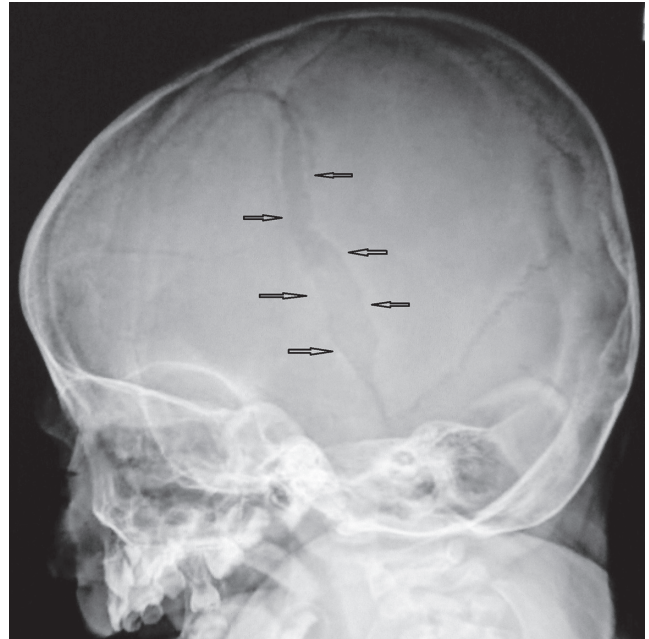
X-ray showed the bone diastasis more than 4 mm
